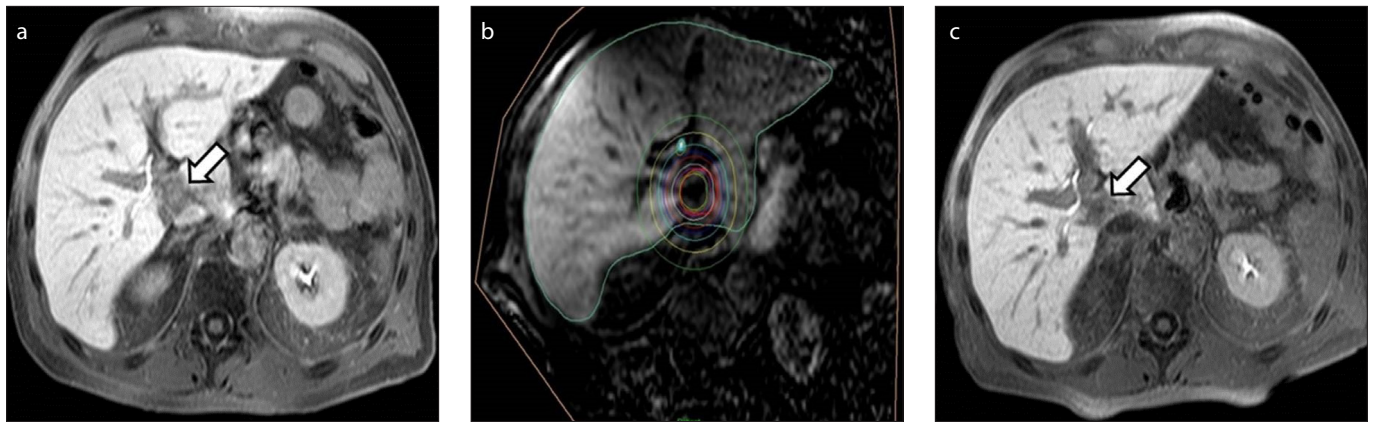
a–c. Local tumor control in a patient with metastatic gastric adenocarcinoma. Axial Gd-EOB-DTPA enhanced T1-weighted image (a) shows metastasis from gastric adenocarcinoma prior to treatment with iBT (*white arrow*); axial Gd-EOB-DTPA enhanced T1-weighted image (b) shows treatment planning with marked target lesion (*red line*), isodose lines (indicates 20 Gy) and the brachytherapy catheter (*white arrow*); axial Gd-EOB-DTPA enhanced T1-weighted image (c) at 3-month follow-up shows local control of treated lesion with new Gd-EOB-DTPA enhancement defect (*white arrow*).
